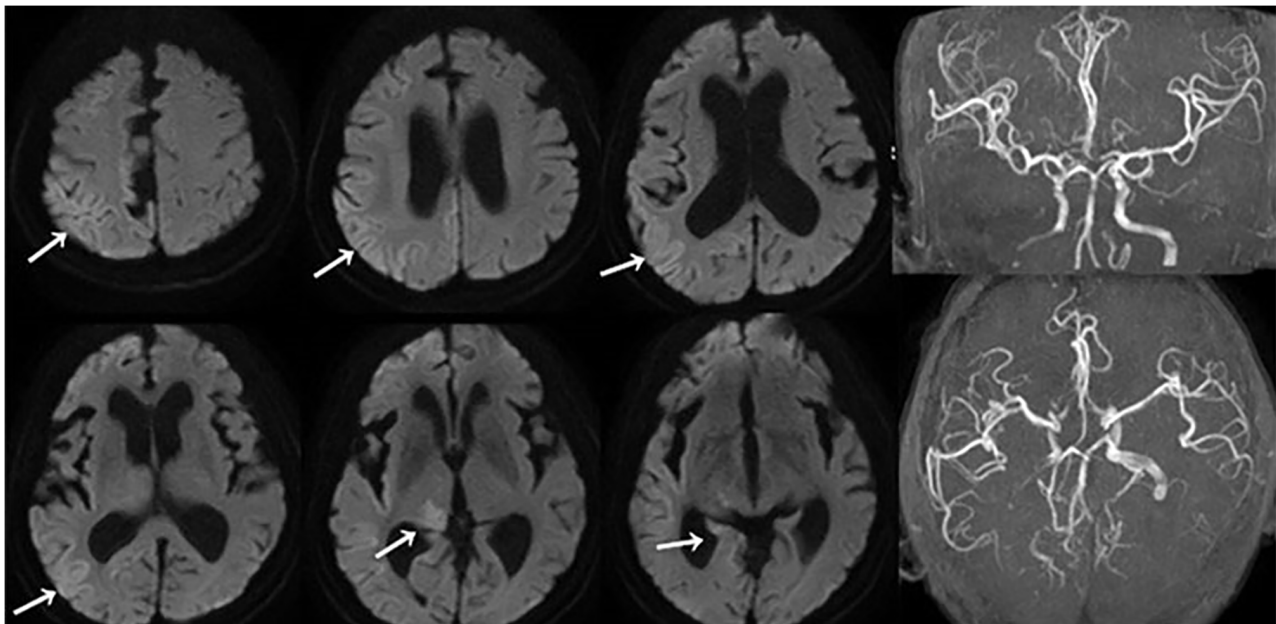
Brain magnetic resonance imaging performed in another hospital in August 2025, 3 days prior to admission to Hebei General Hospital. Brain diffusion-weighted imaging demonstrates acute changes in the right thalamus and fronto-temporo-parietal cortex (white arrow).
